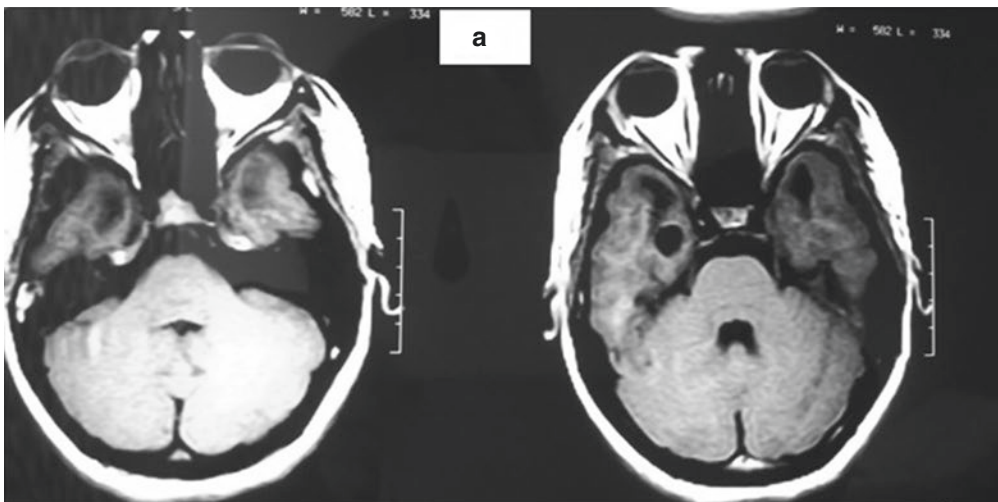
MRI findings of patient with *RNASET2* mutation: (a) Bilateral temporal lobe cysts; (b) Few fine calcification in bilateral frontal region; (c) T2 images showing white matter changes in bilateral frontal regions
